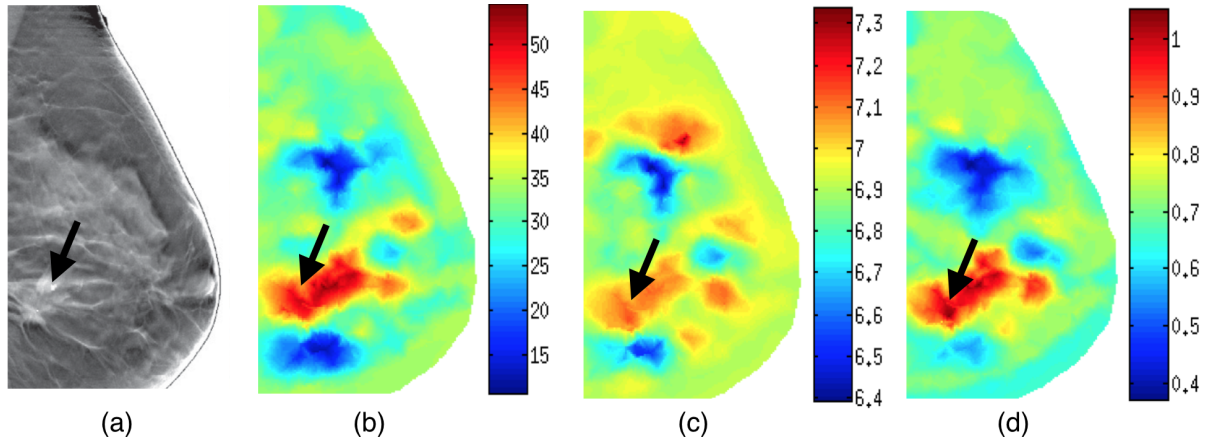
Reconstructed image sections. (a) X-ray image and (b) HbT (micromoles per liter), (c) SO_2 , and (d) μ_s' (cm^{-1}) images at 830 nm. The breast contains a 2.5 cm invasive ductal carcinoma (arrow on a-d).
